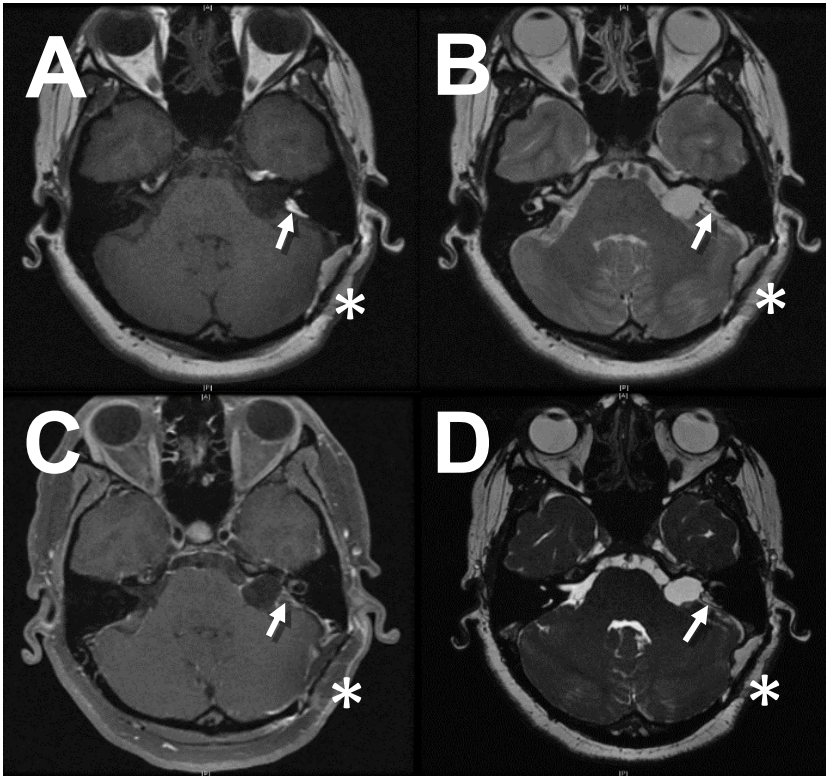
Delayed postoperative axial MRI at 3 months after retrosigmoid transmeatal resection of left acoustic neuroma. Fat graft is in the internal auditory canal (IAC) defect (white arrow) and over retrosigmoid dural closure (asterisk) have both shrunken in size. There is delayed enhancement in the fat graft with gadolinium administration (arrow, C). FIESTA imaging (D) shows clarifies that the enhancing signal is actually fat graft signaling, and that there is no evidence of tumor recurrence. The enhancement is likely postoperative changes from neovascularization. A: T1-weighted MRI, fat is hyperintense. B: T2-weighted MRI, fat is hyperintense with rim of hypointensity. C: Post-gadolinium fat-suppressed T1-weighted MRI, fat signal drops out and there is rim of hyperintensity from postoperative changes. D: FIESTA MRI, fat is hyperintense with a rim of hypointensity.
